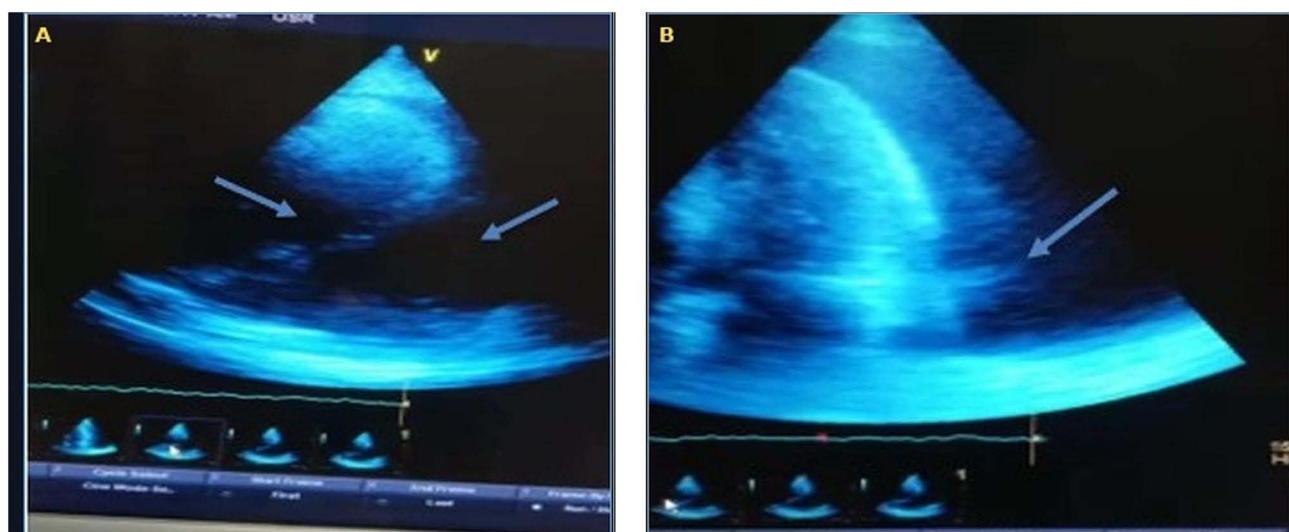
Transthoracic echocardiography demonstrating pericardial effusion with tamponade physiology. (A) Apical 4-chamber view showing large circumferential pericardial effusion (arrows); maximum posterior separation 3.2 cm. (B) Parasternal long-axis view showing posterior echo-free space (arrow) with right ventricular diastolic collapse.
